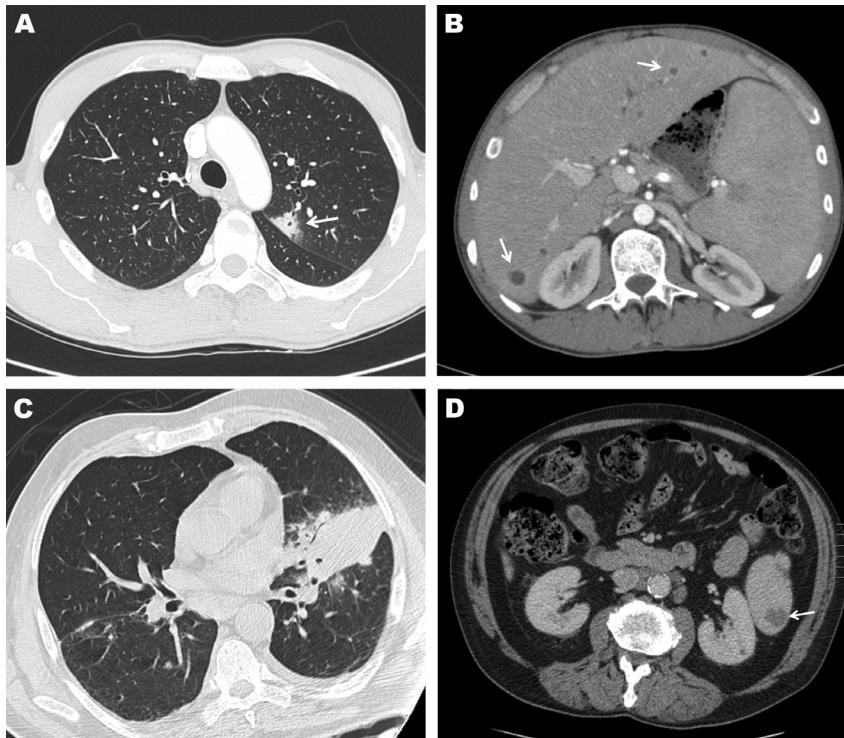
Computed tomography (CT) images of the chest and abdomen of case-patient 1 showing A) a subpleural nodular and cavitary lesion (arrow) in the left upper lobe of the lung and B) multiple small round liver abscesses, seen as multiple foci of ill-defined areas of hypoattenuation (arrows), and enlargement of the spleen. CT images of the chest and abdomen of case-patient 2 showing C) a focal area of parenchymal consolidation in the left lung associated with an ipsilateral mild pleural effusion and D) and a spleen abscess (arrow).
